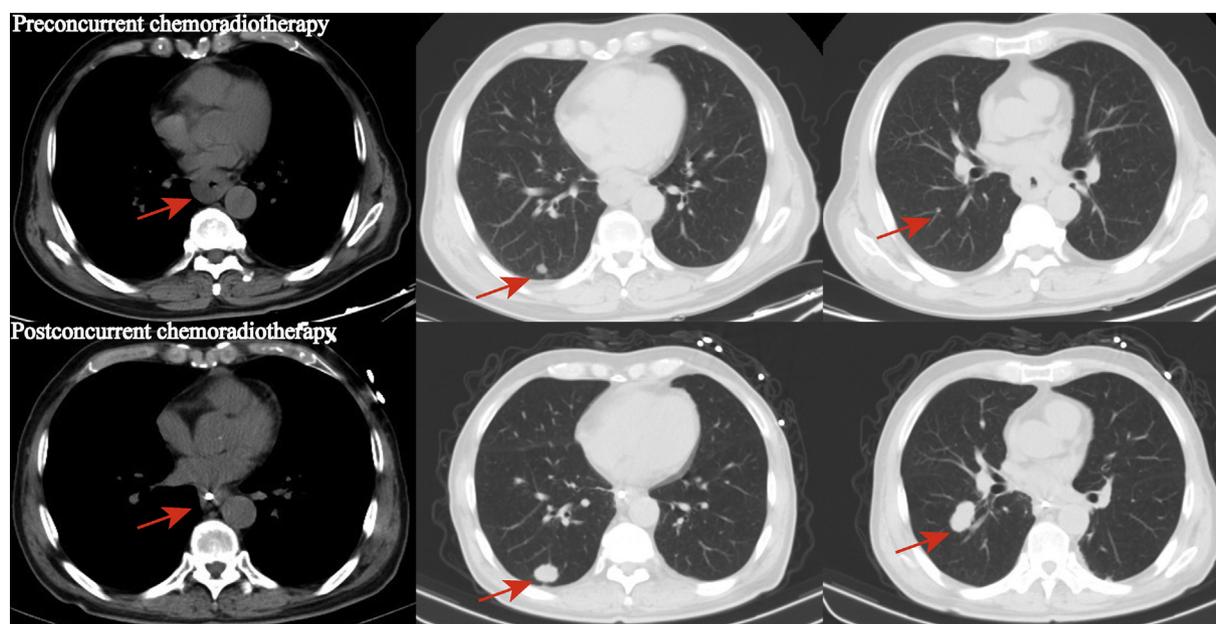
Computed tomography images of esophageal cancer and lung metastasis before and after concurrent chemoradiotherapy. The left two images: the esophageal lesions responded to chemoradiotherapy after treatment (arrows). The middle two images: the pulmonary metastatic lesion enlarged after chemoradiotherapy (arrows). The right two images: the pulmonary metastatic lesion enlarged after chemoradiotherapy (arrows).
